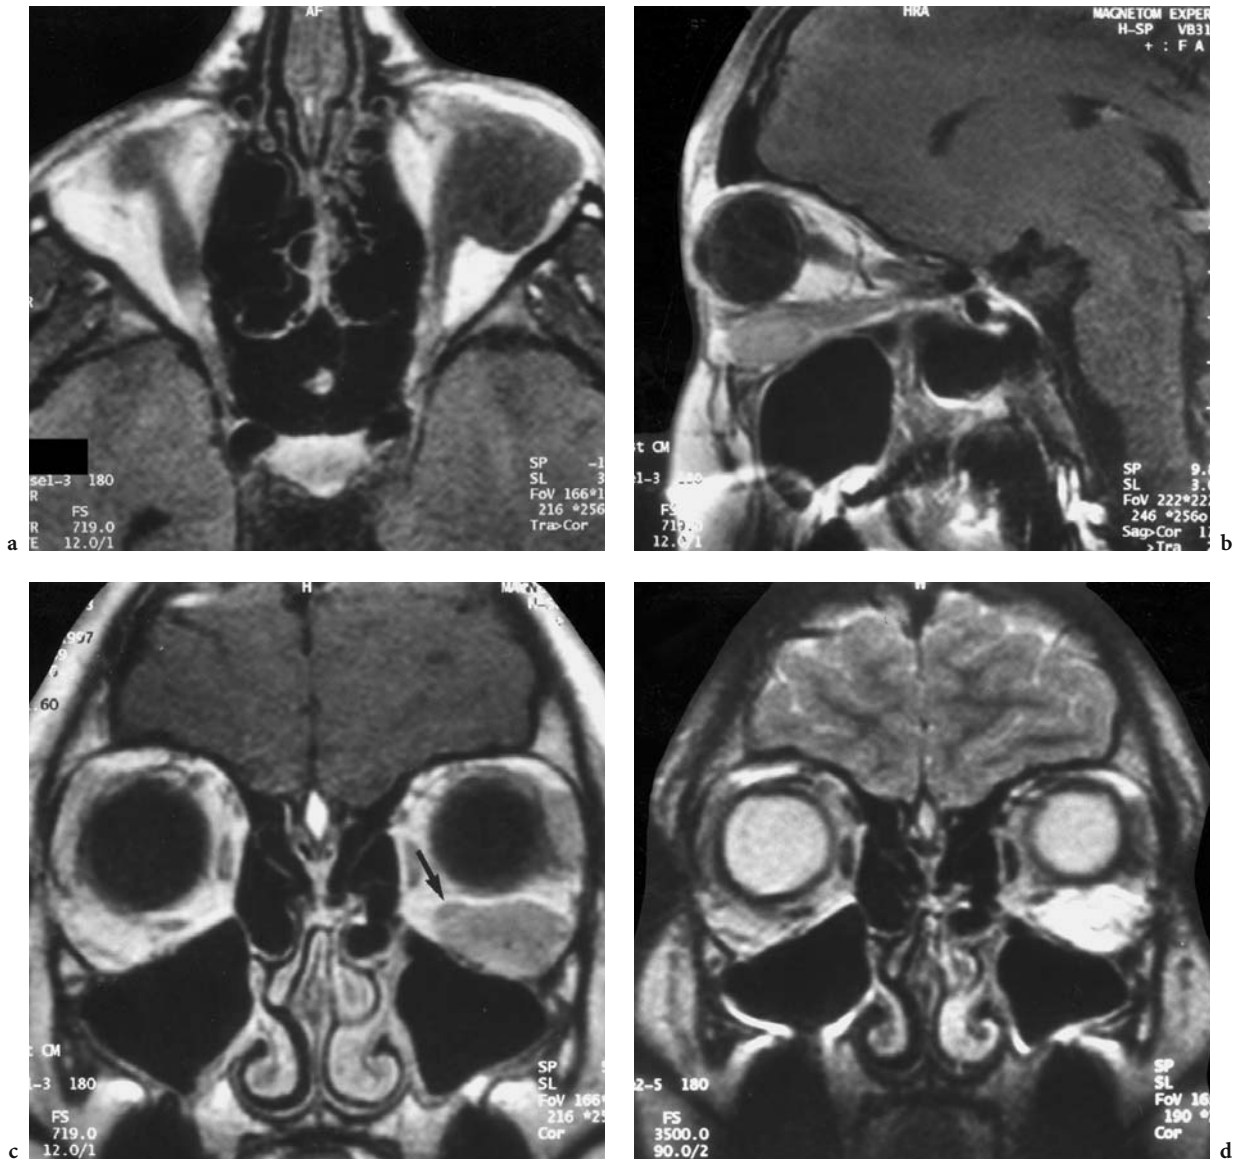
A 14-year-old boy with initial complaint of double vision followed by painless protrusion of the left eye after 1 week. Diagnosis: rhabdomyosarcoma. MRI: a Axial T1-weighted native view of the inferior region of the orbit, showing isointensity of the tumor lateral to the inferior rectus muscle. Differentiation from the muscle cannot be made. b Parasagittal, T1-weighted, contrast-enhanced (FS) view where the tumor appears to depress the inferior rectus muscle from caudal. c Coronal, T1-weighted, contrast-enhanced image where part of the inferior rectus muscle is demarcated medially (*small arrow*) by increased enhancement of the tumor compared with enhancement of the muscle. d Corresponding T2-weighted-image with demarcation of the tumor from the inferior rectus muscle, occupying the inferior, lateral region of the orbit
